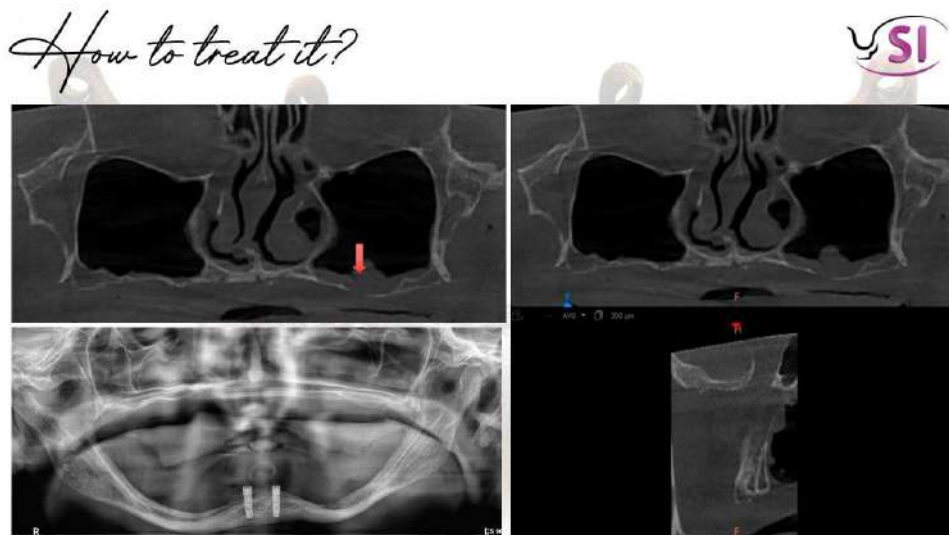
CBCT evaluation: extreme maxillary resorption.
